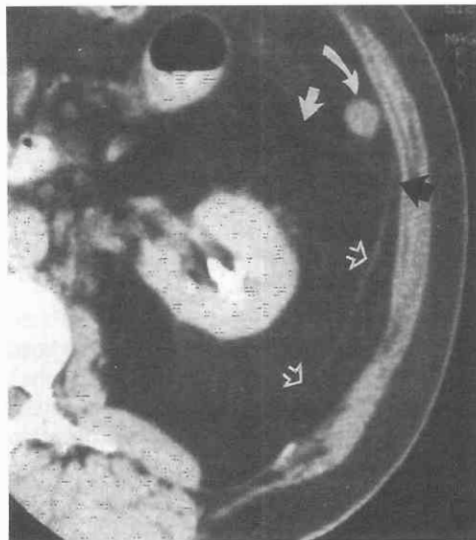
Normal CT anatomy. The posterior renal fascia (open arrows) separates the perinephric and posterior paranephric spaces. The anterior renal fascia (straight white arrow) separates the perinephric and anterior paranephric spaces. The lateroconal fascia (black arrow) extends lateral to the descending colon (curved arrow).
